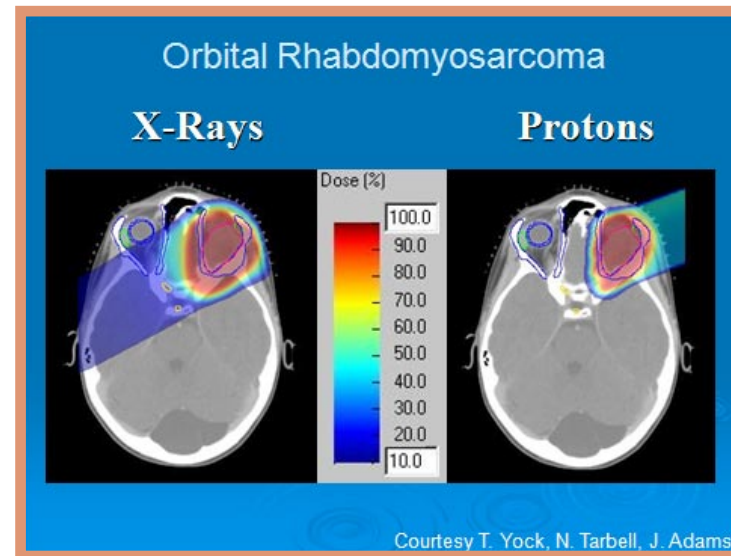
Example of proton therapy for a rare orbital tumour in a child at Massachusetts General Hospital, Boston, USA. The X-ray comparison shows how that beam deposits radiation dose to a much wider area, with consequent risks of future toxicity such as bilateral blindness.
